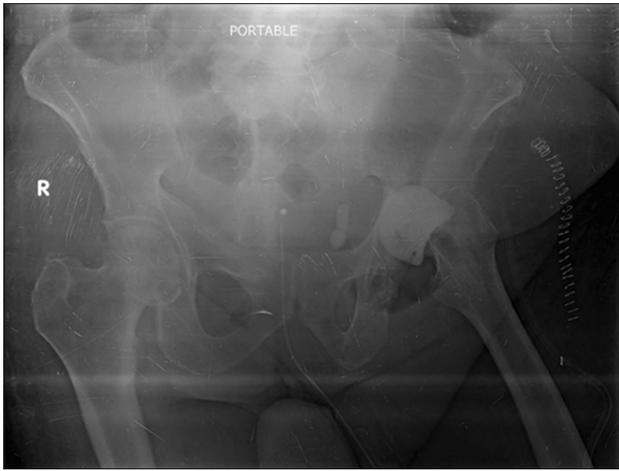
Immediate postoperative X-ray after debridement and excision arthroplasty with gentamicin cement spacer insertion. The entire diseased femoral head and neck was excised, along with the diseased portions of the acetabulum
